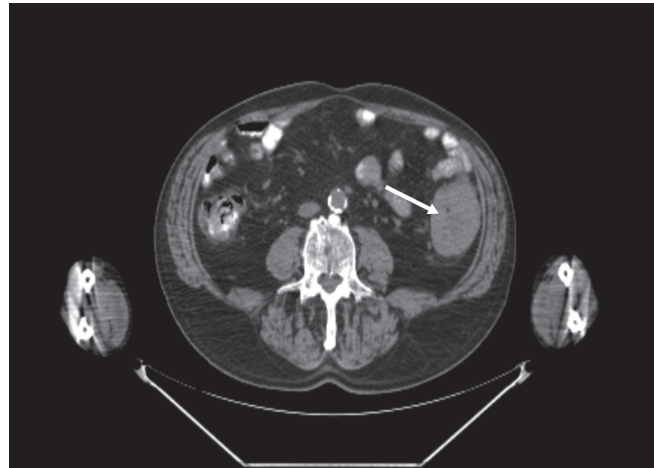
Abdominal computed tomography imaging without contrast. Increased tumoral wall thickness in the descending colon extending to the surrounding adipose tissues (arrow).
